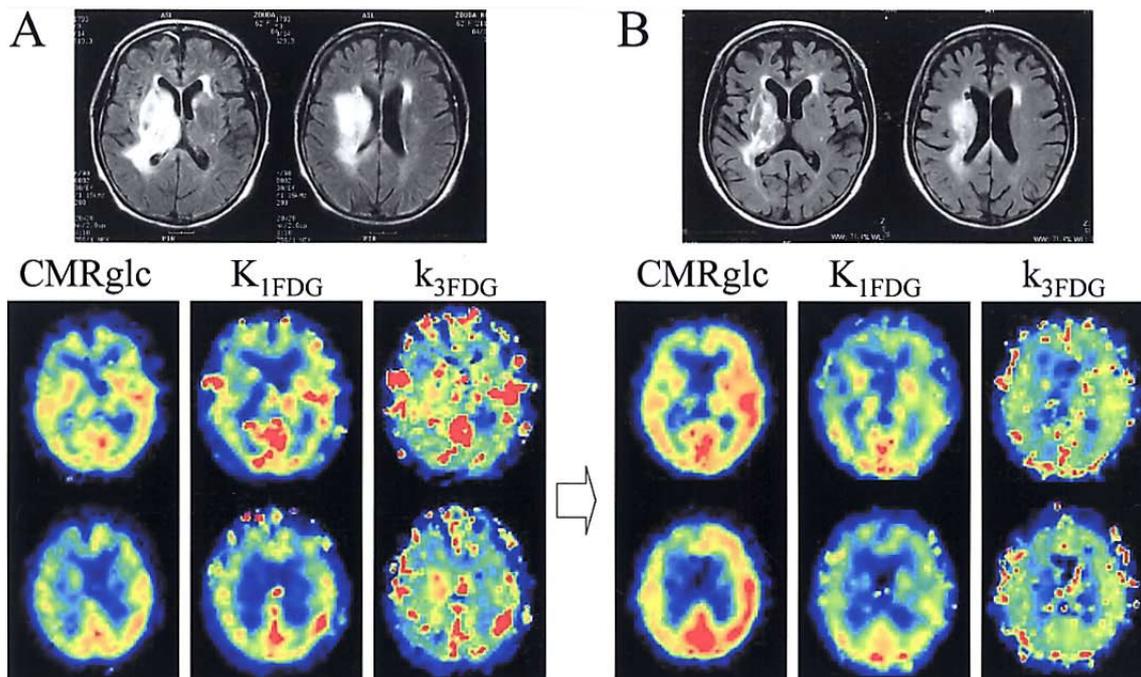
[^{18}F]FDG-PET kinetic analysis before (A) and after (B) the treatment with high-dose methotrexate in combination with CHOP chemotherapy. [^{18}F]FDG-PET images displayed an insignificant increase in FDG uptake in the lesions compared with the contralateral brain. Kinetic analysis of this scan showed decreased FDG transport (K_1) and increased hexokinase activity (k_3) in the lesions compared with the contralateral brain. After the first chemotherapy, [^{18}F]FDG-PET study showed decreased FDG uptake in the lesions compared with that obtained before the chemotherapy and kinetic analysis of this study revealed increased FDG transport (K_1) and decreased hexokinase activity (k_3) compared with those obtained before the chemotherapy.
